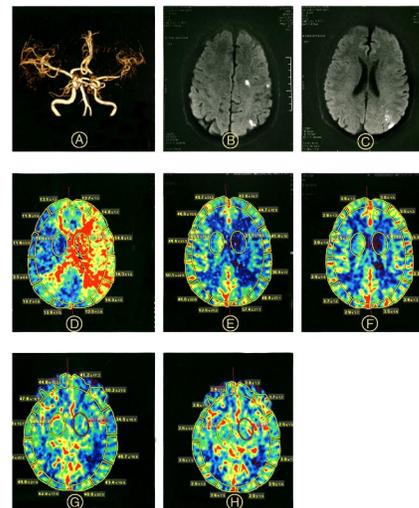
Case 2, male, aged 41, left limbs activity problems for 8 hours, (A) The left middle cerebral artery was stenotic. (B and C) DWI showed multiple infarction focus in left temporal parietal. CTP showed TTP(D) was obviously abnormal. After treatment, rCBF(G) and rCBV(H) were improved than rCBF(E) and rCBV(F) before treatment.
